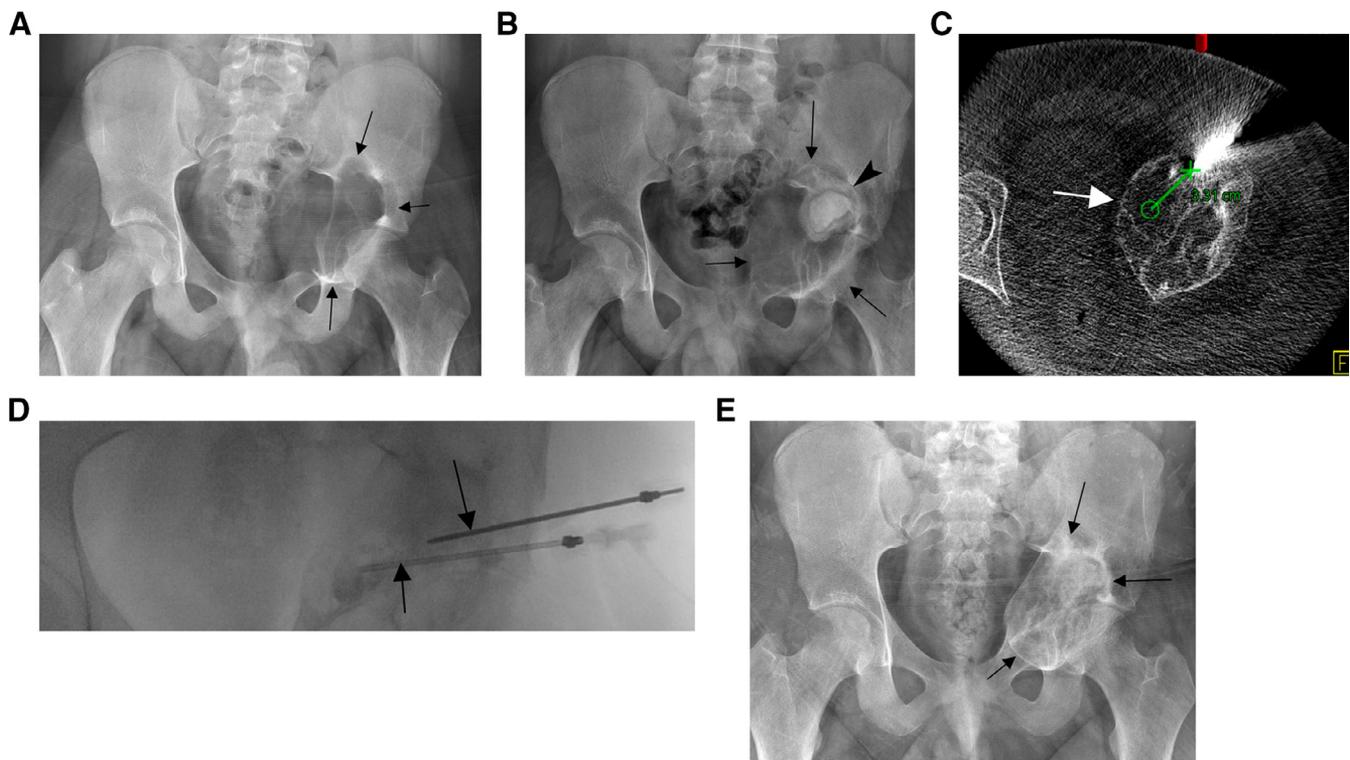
Adolescent male with expanding lucent lesion (black arrows) of the left acetabulum on initial radiograph (A), confirmed as aneurysmal bone cyst on open biopsy and curettage. A large residual component (black arrows) on 4-month postoperative radiograph (B), with graft material noted at the superior lateral aspect (black arrowhead). Following percutaneous biopsy (not shown), sclerotherapy at 2 sites with a total of 18 mL/180 mg of Doxycycline foam was performed. Cone Beam CT with guidance software (C) was used to target and treat all components of the ABC (white arrow). Note the introducer needles on fluoroscopy (D). Follow-up pelvic radiograph at 2 months post-treatment (E) shows interval sclerosis (black arrows) consistent with interval healing of the ABC. Patient was able to return to full weight bearing status following ABC healing. (Images used with permission of Dr. Abhay 'Finn' Srinivasan).
